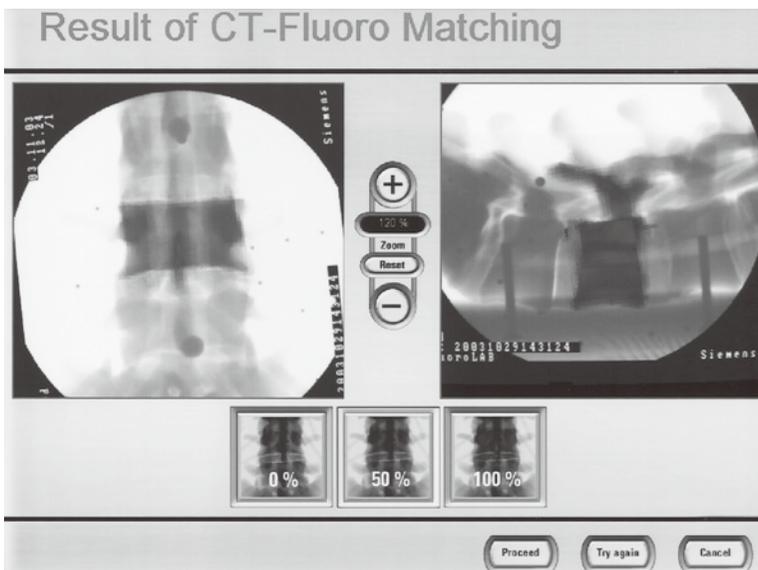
Result of CT-fluoro matching. Once vertebra has been correctly positioned, pressing a button to confirm placement activates automatic matching, at which point CT-fluoro matching procedure is displayed.
